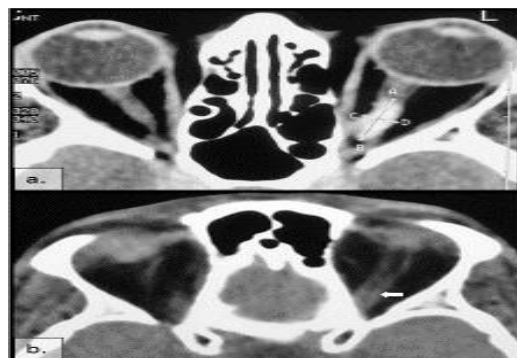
Computed tomography of orbit showing a diffuse calcified mass in left optic nerve, sparing the apex & the eye ball, b: Tram track appearance of the tumor
